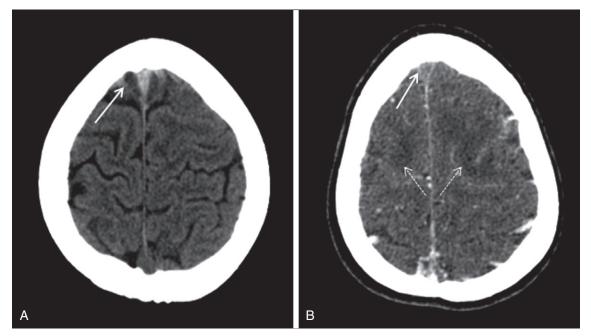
Patient presenting with change in mental status with sinus thrombosis. A, Unenhanced CT delineates a hyperdense anterior portion of the superior sagittal sinus (*arrow*), suggesting venous sinus thrombosis. B, Contrast-enhanced CT confirms lack of opacification of the anterior portion of the superior sagittal sinus (*arrow*) and associated areas of cortical hypodensity/ischemia (*diverging dotted arrows*).
